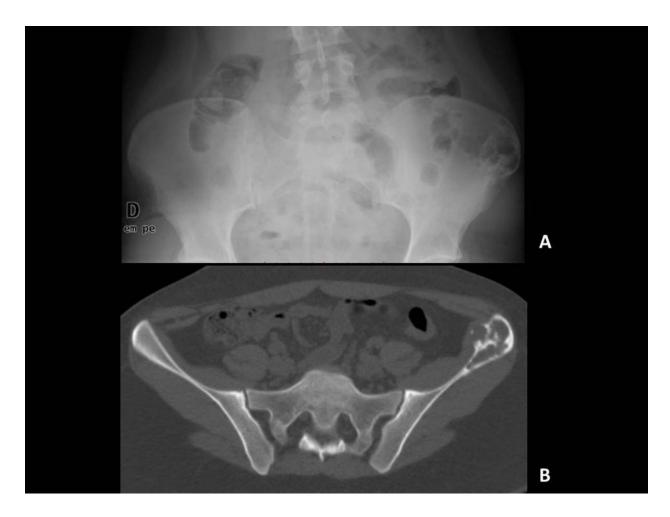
Conventional chondrosarcoma. Anterior-posterior radiography (A) and CT (B) of the left iliac bone shows a lytic lesion with chondroid matrix mineralization and endosteal scalloping.
